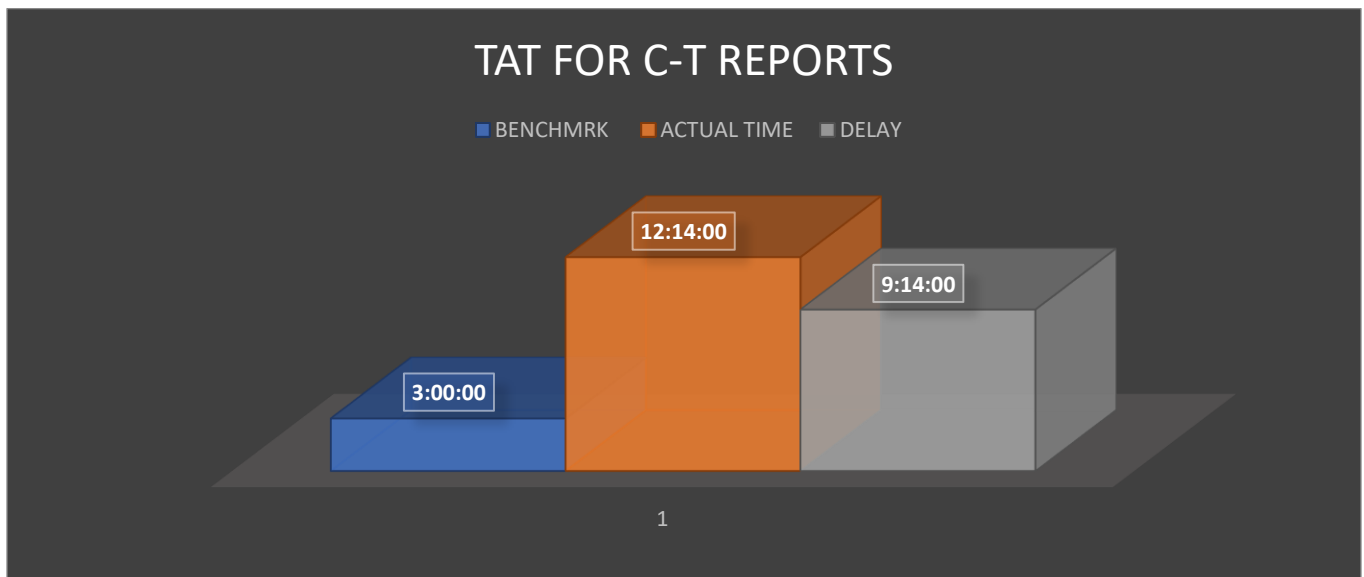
Represents the Turnaround time for the CT reports for the month of Feb.
